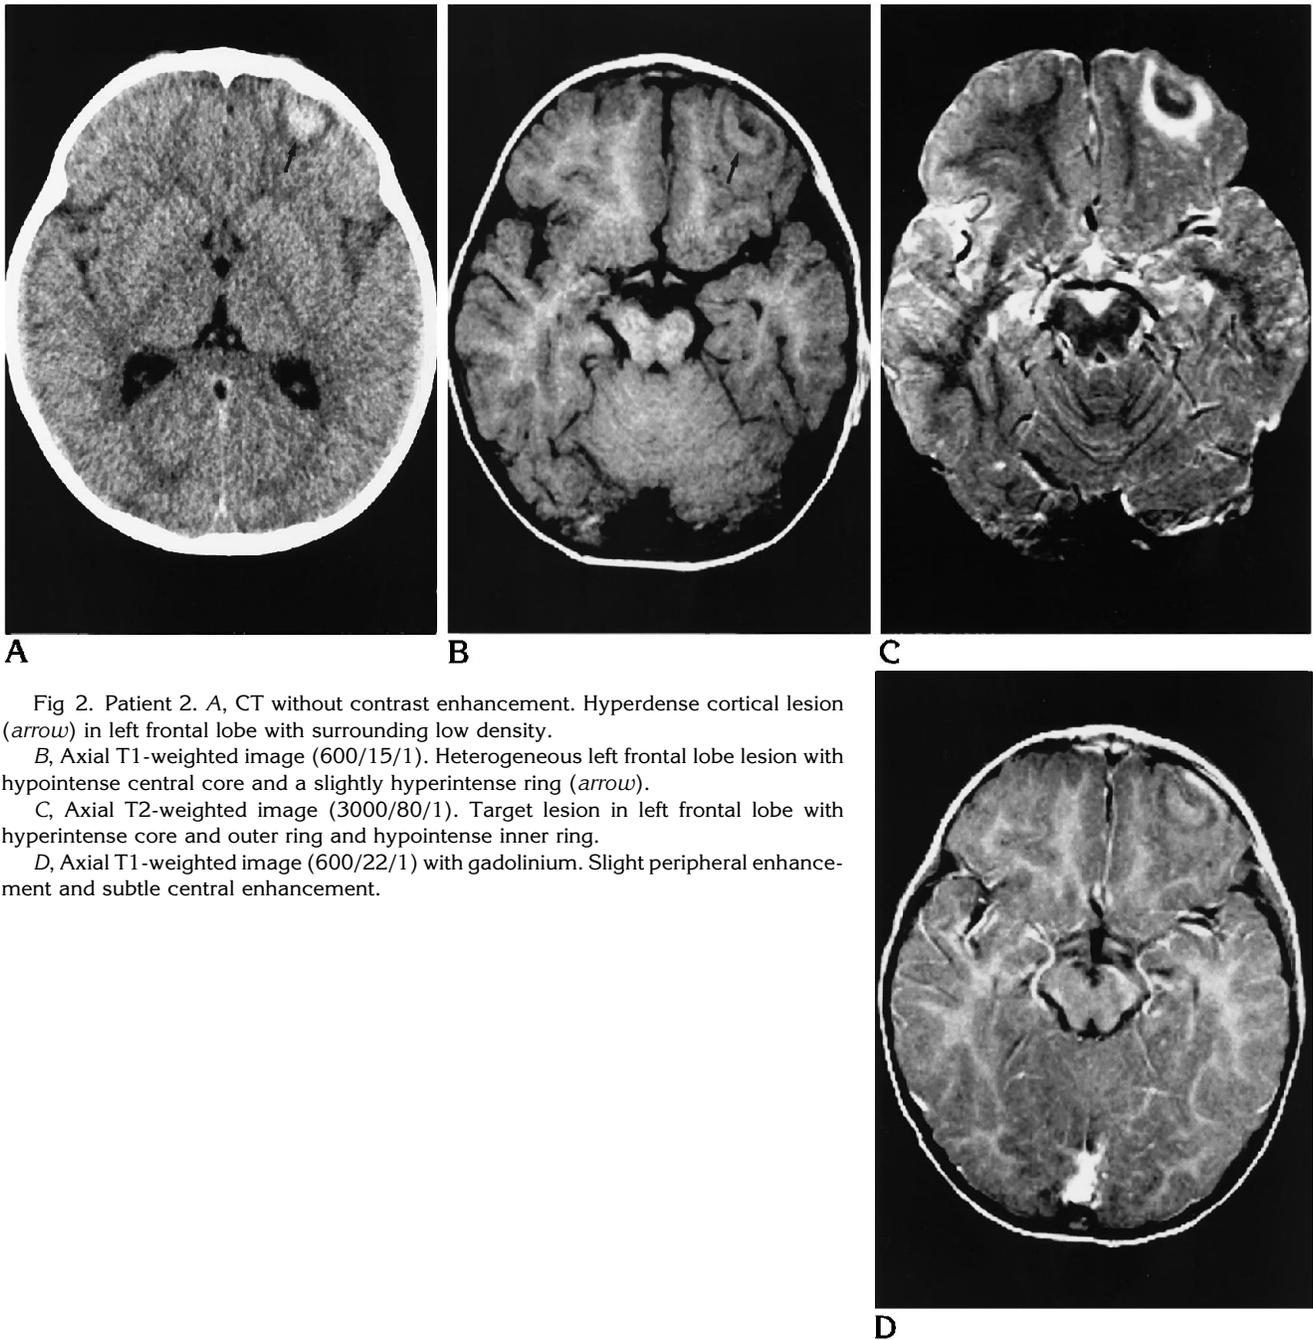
Patient 2. A, CT without contrast enhancement. Hyperdense cortical lesion (*arrow*) in left frontal lobe with surrounding low density.
